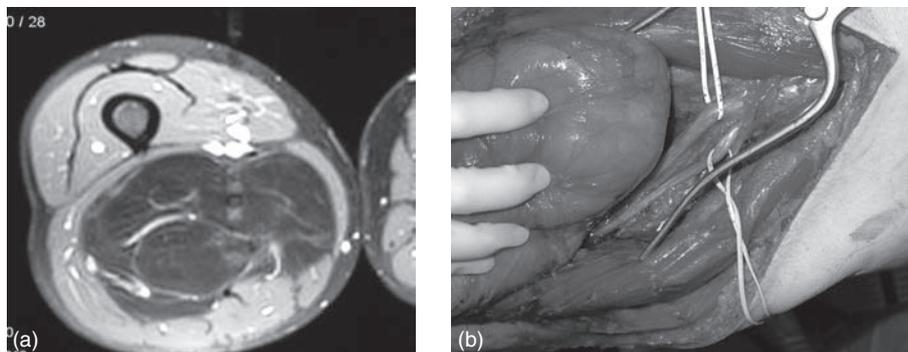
Magnetic resonance image of chondrosarcoma arising from rectus femoris. Note the close proximity to the superficial femoral vessels.
